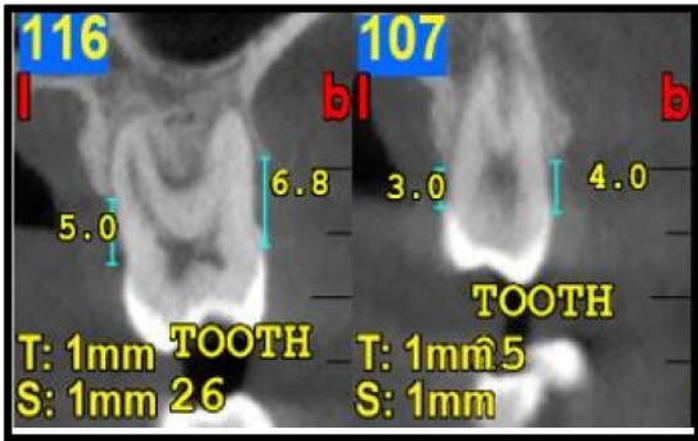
PRE-OP CBCT IBD Measurements
